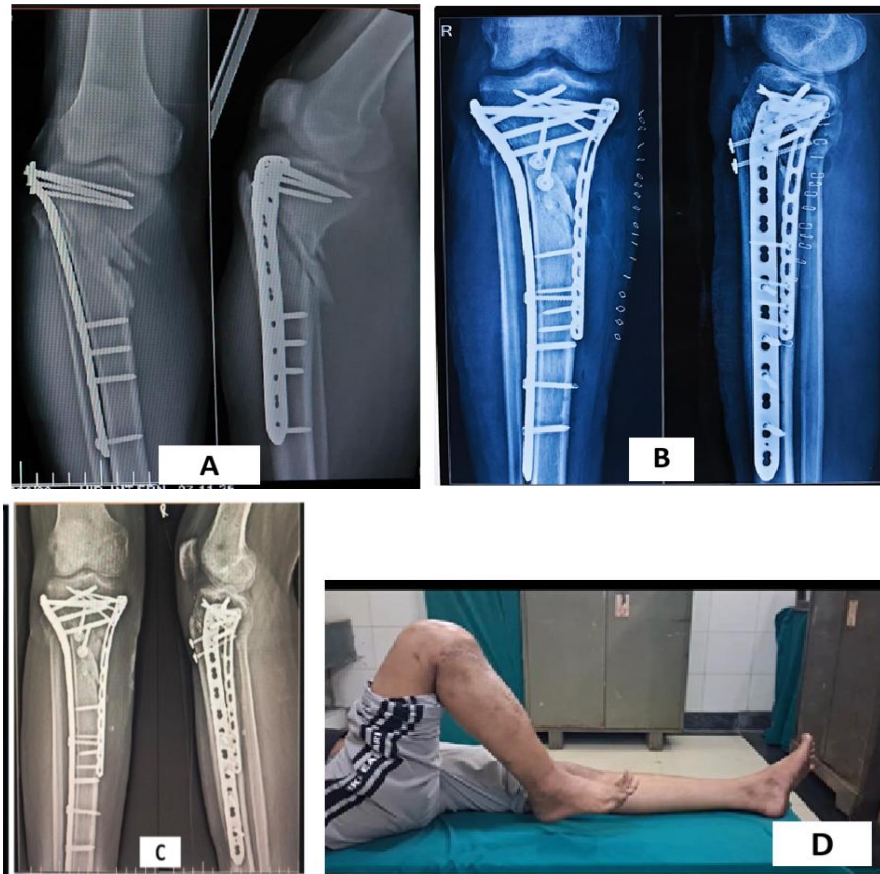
(A): Preoperative radiographs of a 36-year-old male showing implant failure in proximal tibia; (B): immediate postoperative radiograph showing revision osteosynthesis with dual plating to counteract varus forces; (C): radiographs at 2 months showing progressing consolidation and (D): clinical photographs demonstrating restored limb axis and excellent joint mobility.
